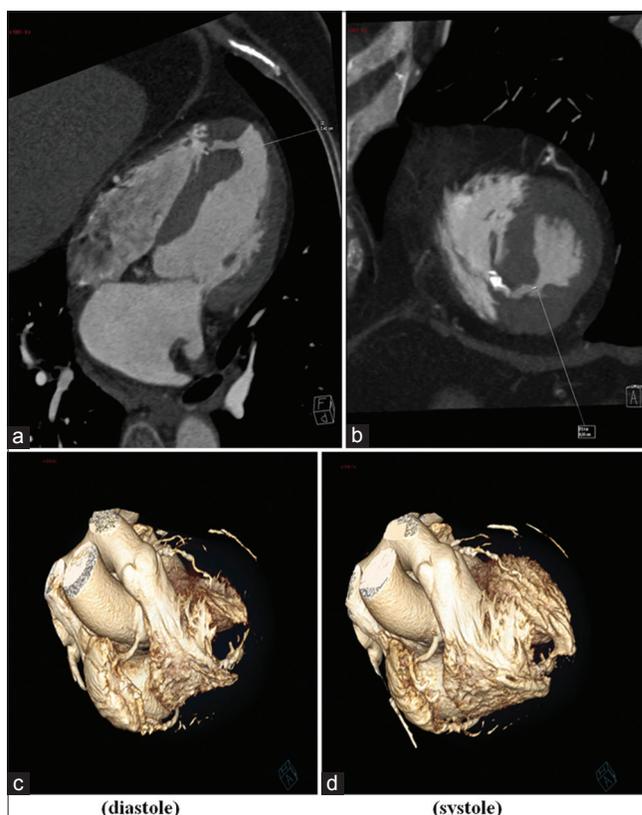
Computed tomography scan with three-dimensional reconstruction: Evidence of lateral apical and septal disinsertion
